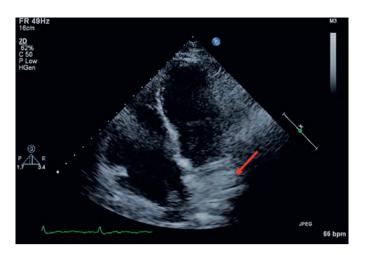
Echocardiography showing right atrial mass (red arrow).
